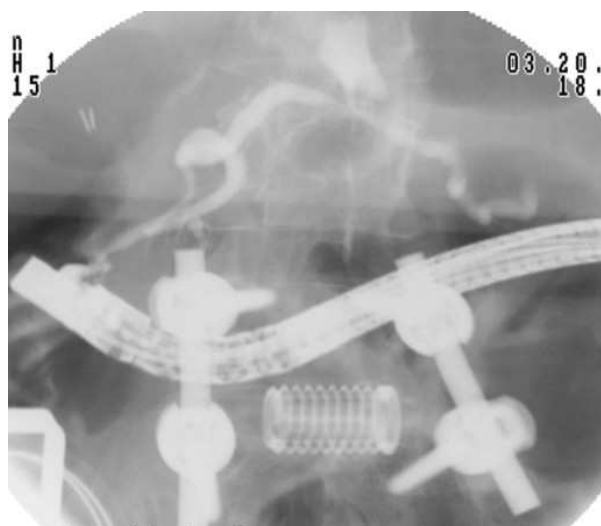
Radiographic image showing endoscope in position passed retrograde. A pancreatic leak is identified and is identical to the MRI.
